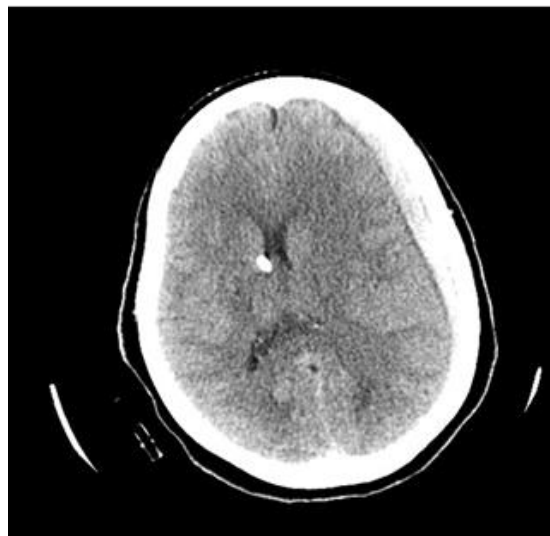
CT brain showed a large acute subdural hematoma.
